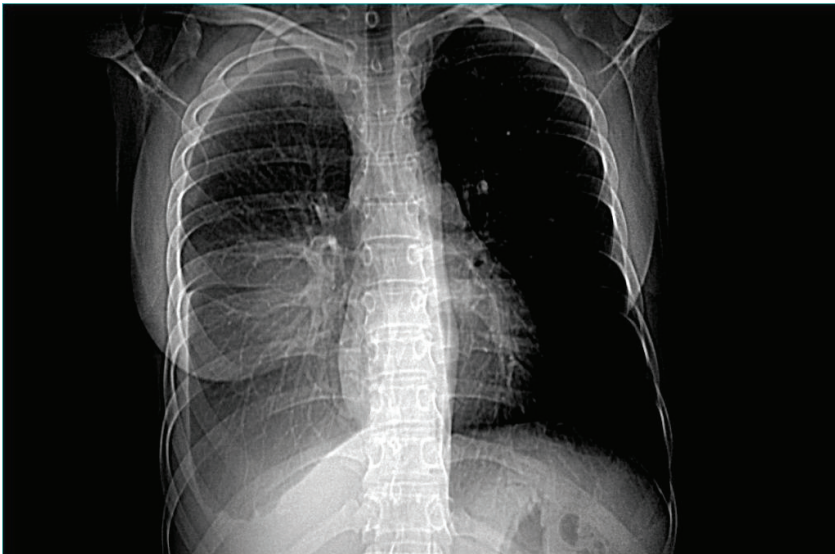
CT scan of thorax (frontal section). Hydrothorax to the level of the apex of the right lung and tumor in size of $7 \times 13 \times 13$ cm in lower lobe of right lung, atelectasis of lower lobe of right lung.
